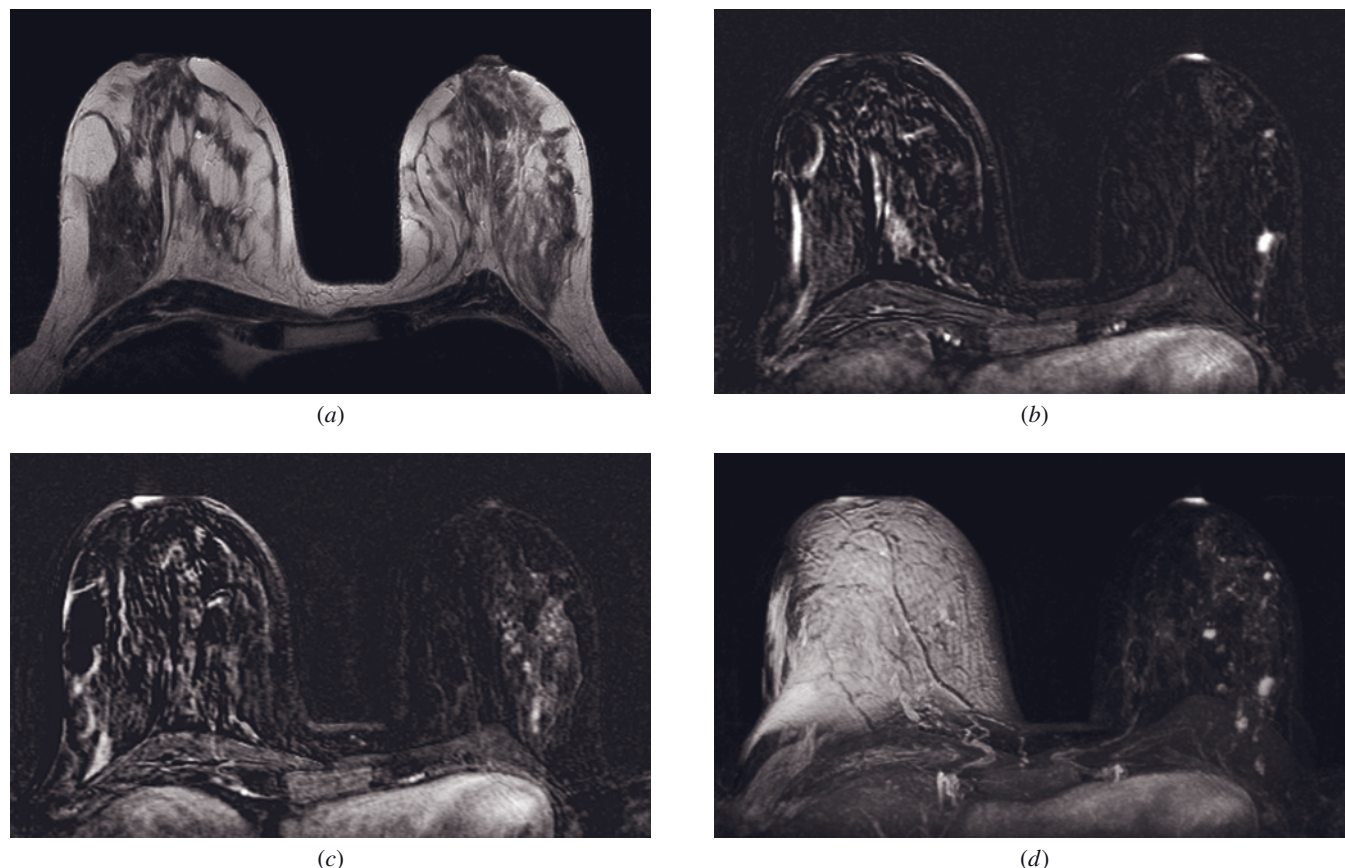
Multicentric invasive lobular carcinoma (ILC). Axial T2-weighted (*a*) image shows a single hypointense mass in the upper outer quadrant of the left breast, located between fibroglandular and subcutaneous fat tissue. Postcontrast subtracted images at the same (*b*) and different (*c*) levels and MIP image (*d*) show several irregularly shaped and oval enhancing subcentimeter lesions in segmental distribution within the left breast. ROI analysis of the dynamic data set (not shown) demonstrated a plateau curve (Type II). Both subtracted and MIP image quality was altered by motion artifacts (imaging was performed at 1.5 T MR unit). Note complete obscuration of the right breast on the MIP image (*d*) due to motion and misregistration. Biopsy revealed multicentric lobular cancer in the left breast (pT1).
